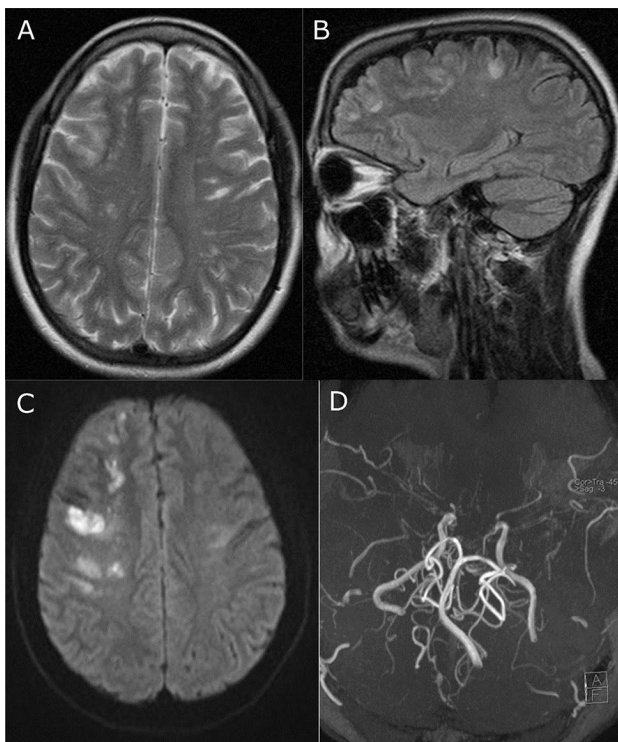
MRI of a female patient begin of 20 misdiagnosed as MS in 2012 a, b despite negative oligoclonal banding in CSF and treated with copaxone for years. c Diffusion weighted images and d MR angiography when diagnosed as Moyamoya angiopathy in 2017
